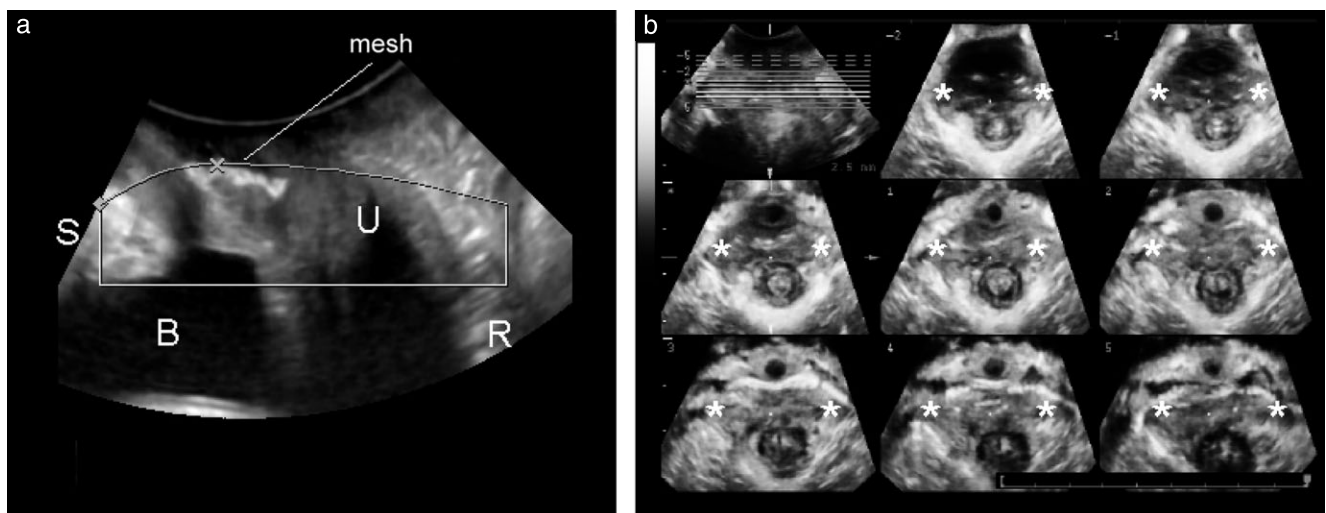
Pelvic floor ultrasound images showing successful cystocele reduction after anterior mesh placement, seen in midsagittal plane (a), in a patient with bilateral avulsion (*) visible on tomographic imaging (b). B, bladder; R, rectal ampulla; S, symphysis pubis; U, uterus.
